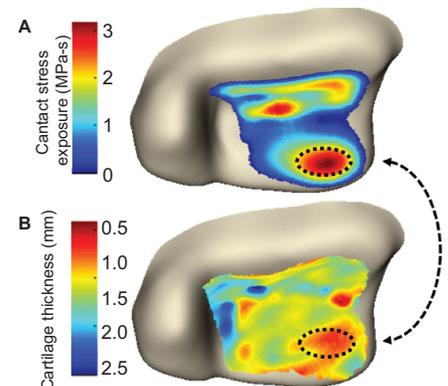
A) These plots depict (A) the contact stress exposure computed from post-op CT and (B) the cartilage thickness measured from contrast-enhanced CT at 18 months post-op over the joint surface. The cartilage showed thinning in areas of substantially elevated contact stress.
